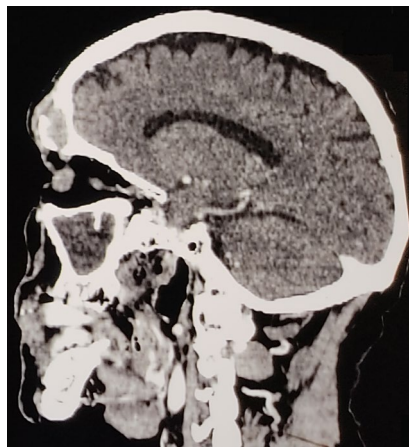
CT brain-sectional (axial) showing ossification of the sinus ethmoidale.
